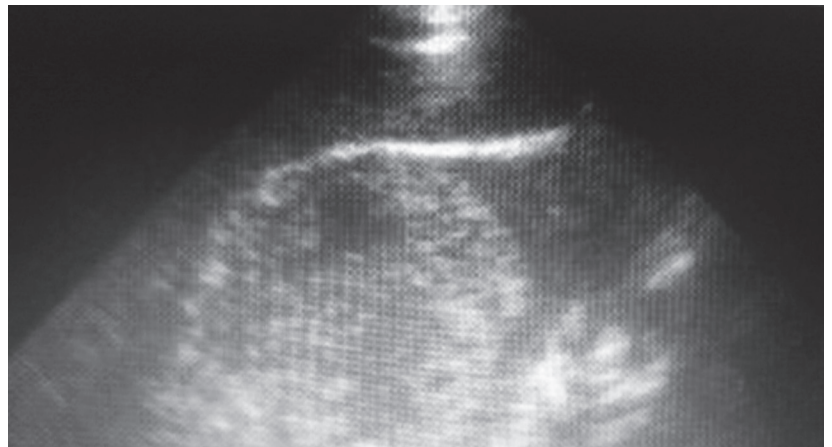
Abdominal ultrasound, showing image of a solid mass in the lower pole of the right kidney.
